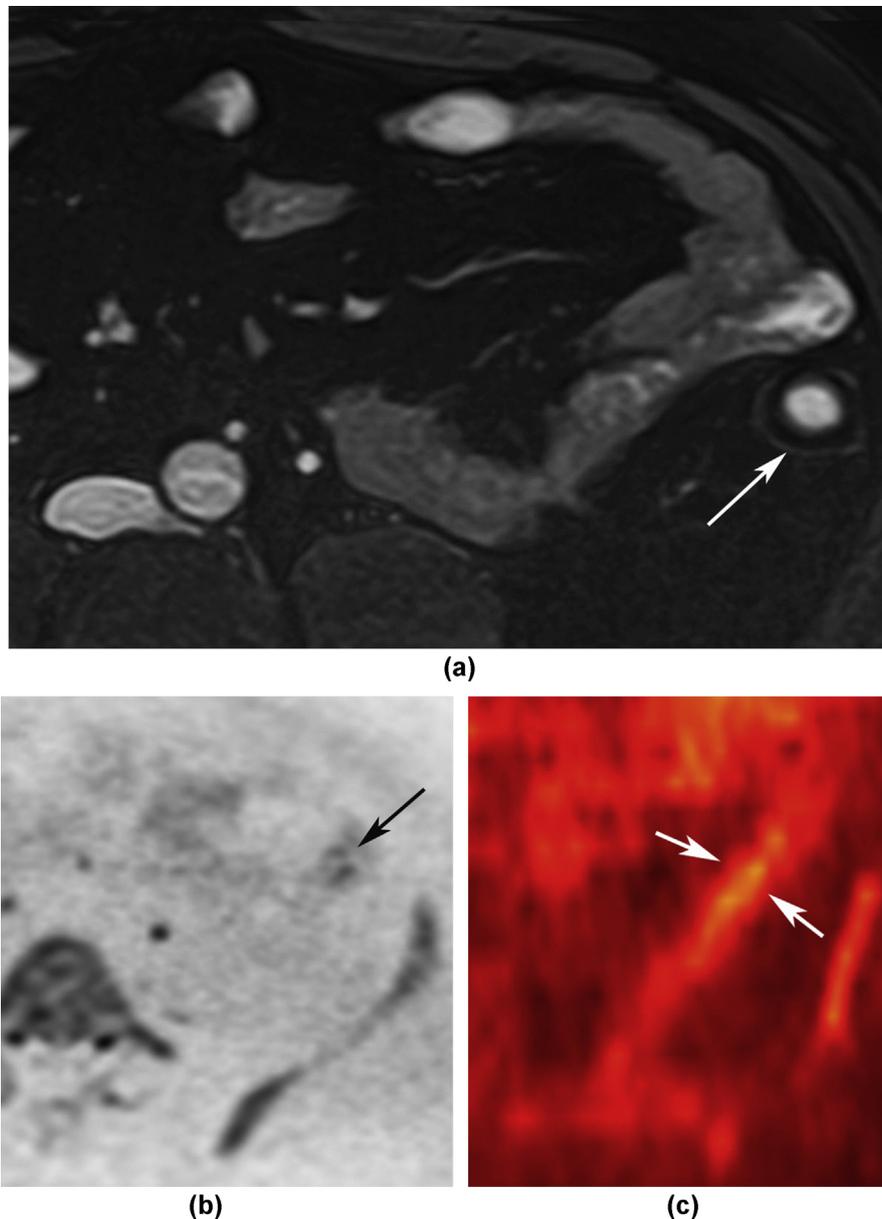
(a) Axial True-FISP image in 46-year-old male shows quiescent disease in the descending colon. (b) Patient could not undergo contrast injection and DW-MR image shows a ‘tram-track’ type high signal in the mucosa indicative of recurrent mucosal inflammation (arrow). (c) Colour coded DW-MR MPR image shows high signal in the mucosa within the thickened bowel (arrows) with greater visibility.
